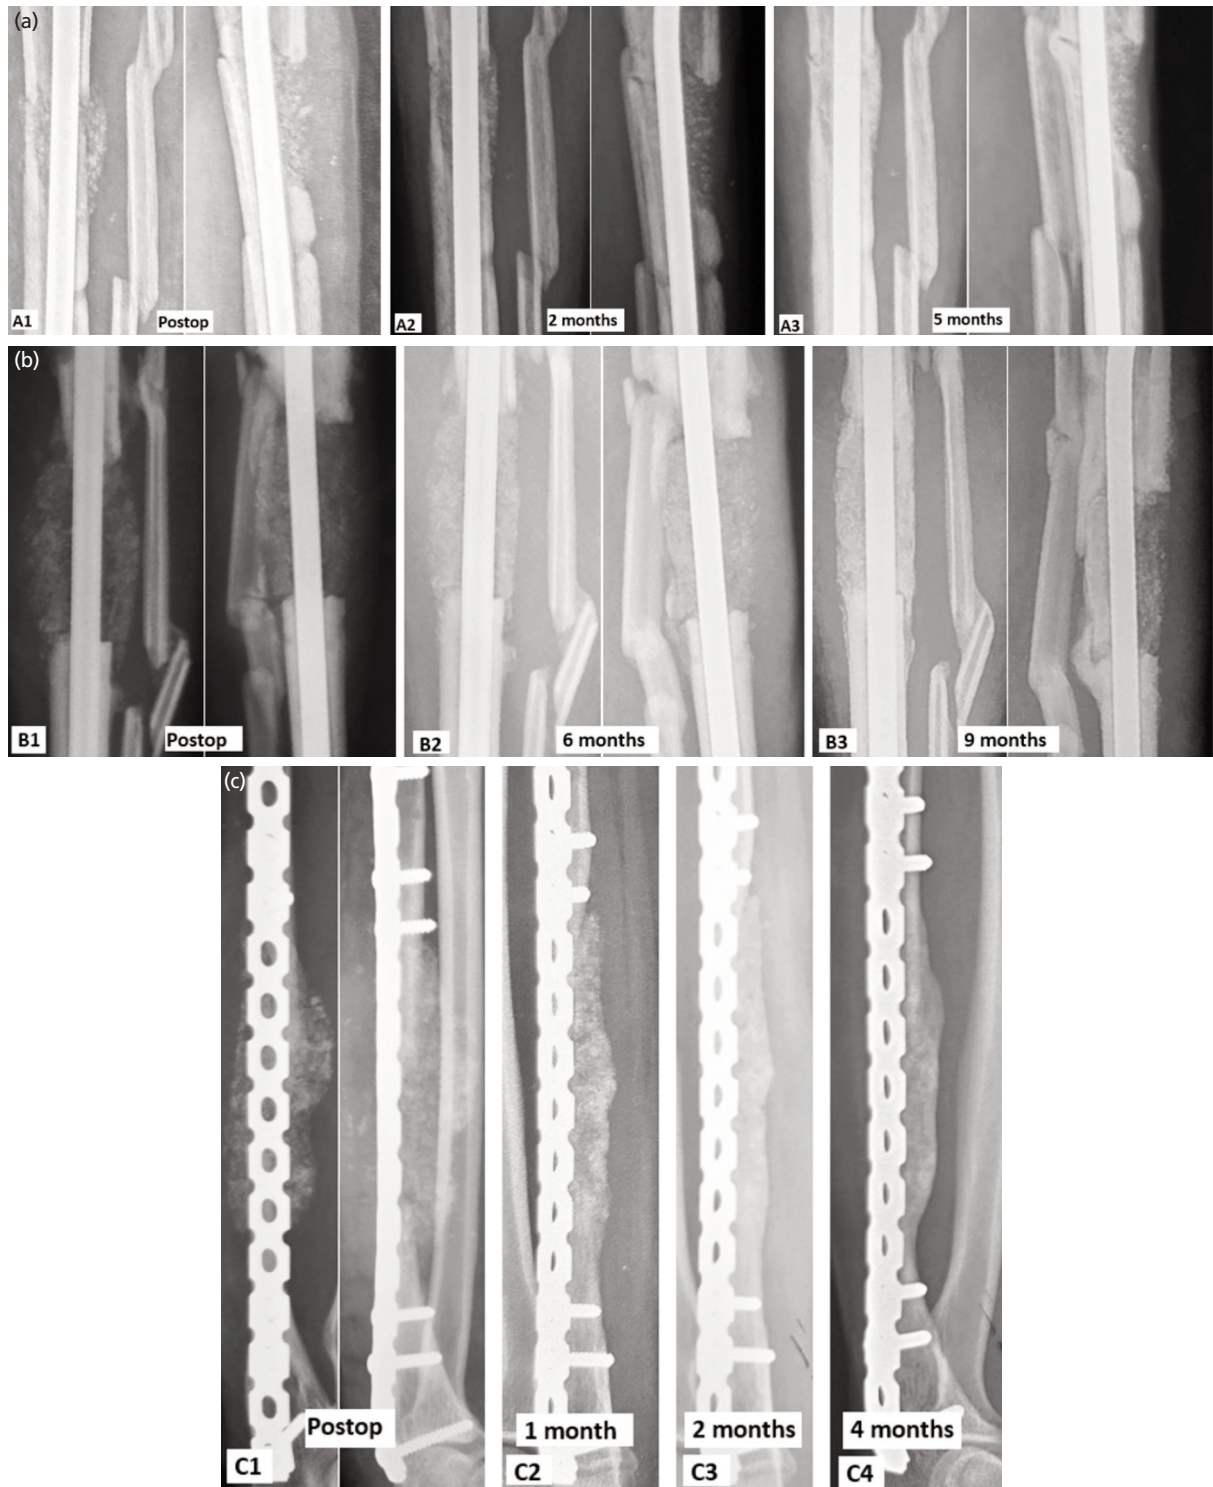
Bone grafting with Masquelet technique shows remodelling over time. (a) Figures belongs to Case 3, A1 shows AP and lateral tibia radiographs immediate after bone grafting. A2 and A3 are 2 and 5 months follow up radiographs. (b) Figure belongs to Case 7, B1 shows AP and lateral tibia radiographs immediate after bone grafting. B2 and B3 are 6 and 9 months follow up radiographs. (c) Figure belongs to Case 8, C1 shows AP and lateral ulna radiographs immediate after bone grafting. C2, C3, C4 are 1, 2, 4 months follow up radiographs, respectively. Common findings are initial shrinkage of bone graft size in diameter, gradual smoothing of graft edges that suggests remodelling, and corticalization of graft demonstrated by radio-opacification matching that of the cortex. Note that the anterior cortex of the tibia (A3, B3) tends to regenerate with thinner bone as compared to other wall of the cortices.
